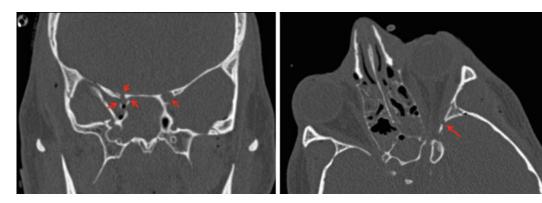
23-year-old-male collided with an SUV while riding a motorcycle. He had a fixed, dilated left pupil. Fractures to the medial orbit, sphenoid sinus roof, and bilateral optic canal fractures involving all 4
